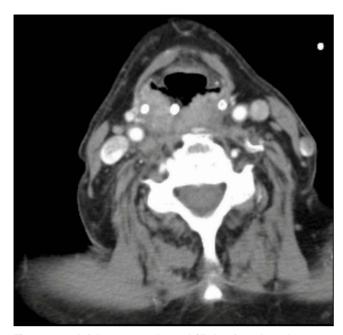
Axial contrast-enhanced CT showing a large hypopharyngeal posterior wall tumour extending on to the prevertebral muscles.
